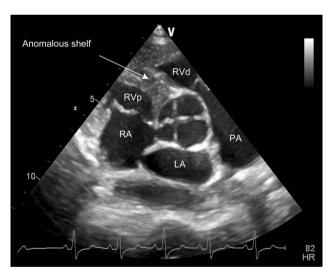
Transthoracic 2-D echocardiogram in parasternal short-axis view in diastole revealing quadricuspid aortic valve and anomalous shelf in right ventricle.
